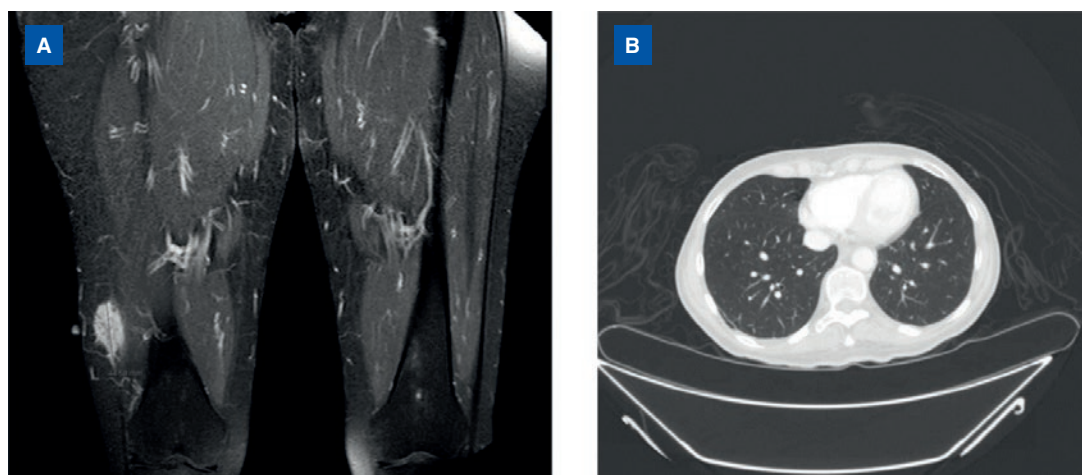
(A) Magnetic resonance imaging (MRI) of the thighs and (B) CT scan of the thoracic region (December 2019).
